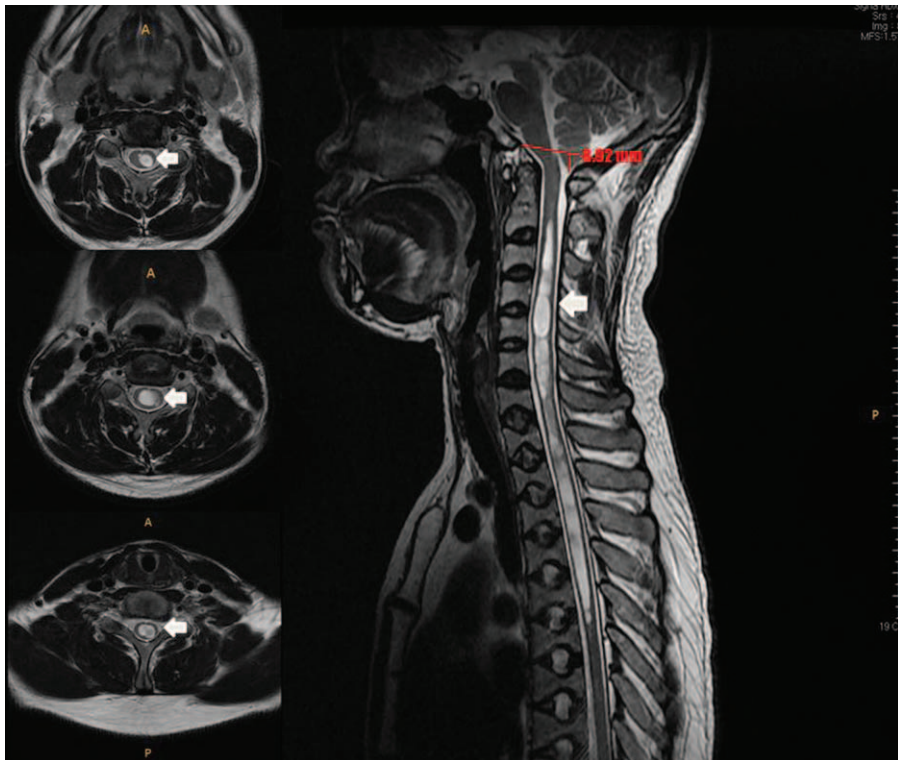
Magnetic resonance imaging showing extensive syringomyelia in the cervical and upper thoracic spinal cord, and mild downward herniation of the cerebellar tonsils. The pear- and biconcave-shape of the bodies of the vertebrae is evident.
